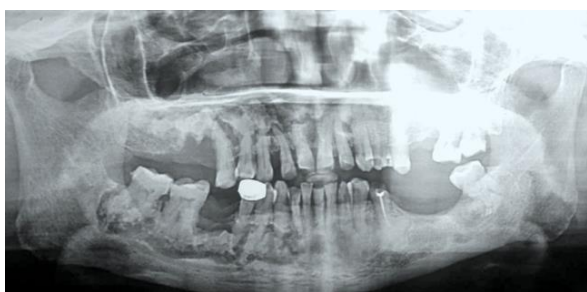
Radiograph showing mixed radiopaque and radiolucent appearance of the alveolar bone.
